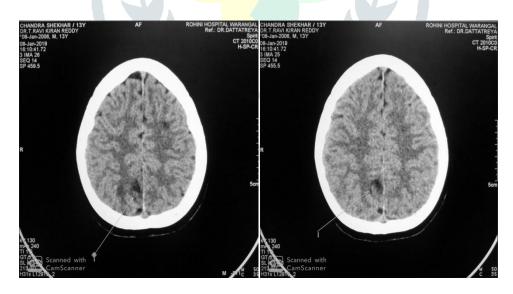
CT scan of brain demonstrating hypodensity in right posterior parietal region and post ictal edema
